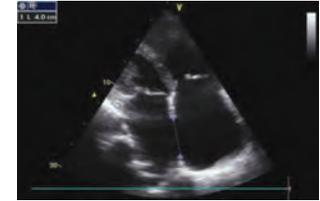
Transthoracic echocardiogram demonstrating atrial septal defect.
